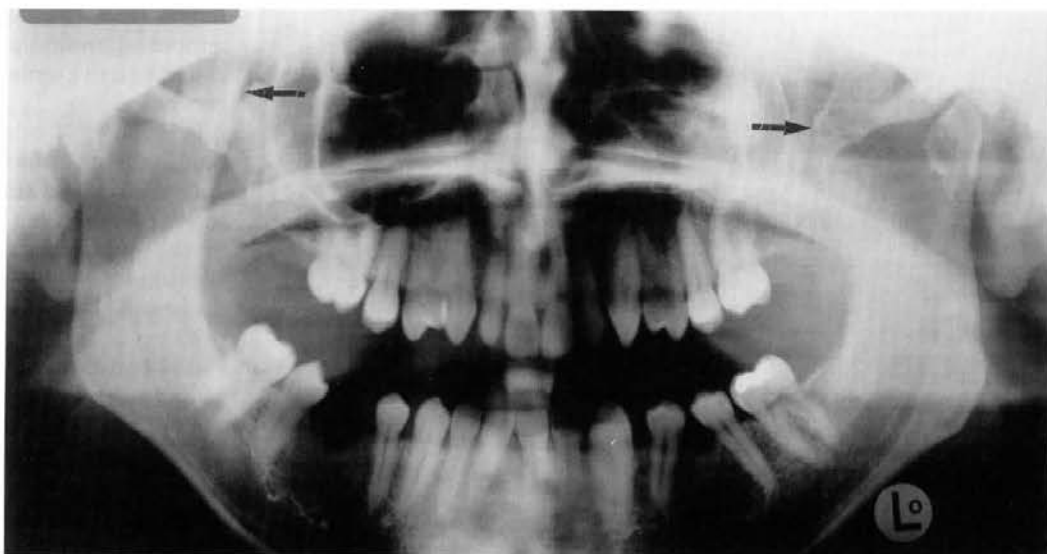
Panoramic radiograph showing coronoid process (arrowed).
